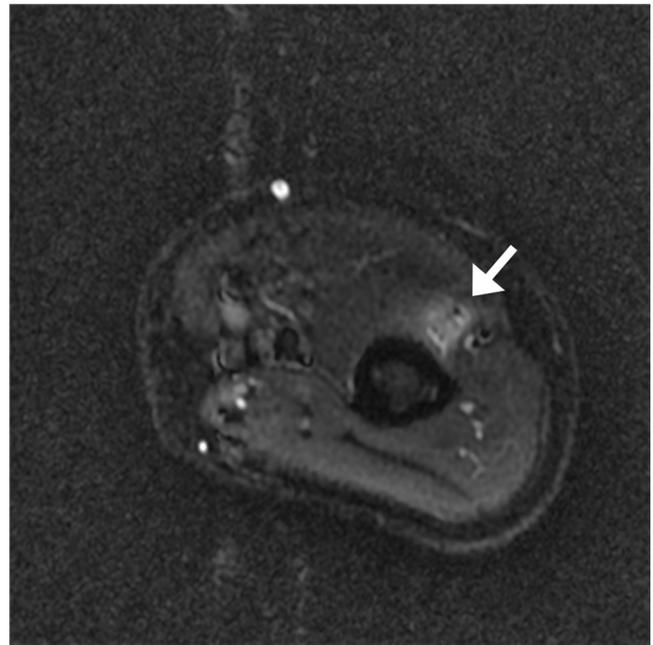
MRI of an affected extremity in a patient with radial nerve palsy. The brachioradialis, extensor carpi radialis longus, extensor carpi radialis brevis, supinator, extensor pollicis longus, abductor pollicis longus, and extensor digitorum were affected, but the triceps brachii were not affected. Sensory disturbance was present at the web of skin between the thumb and index finger. A short inversion time inversion recovery image showing radial nerve high intensity at 50 mm above the lateral condyle (white arrow).
